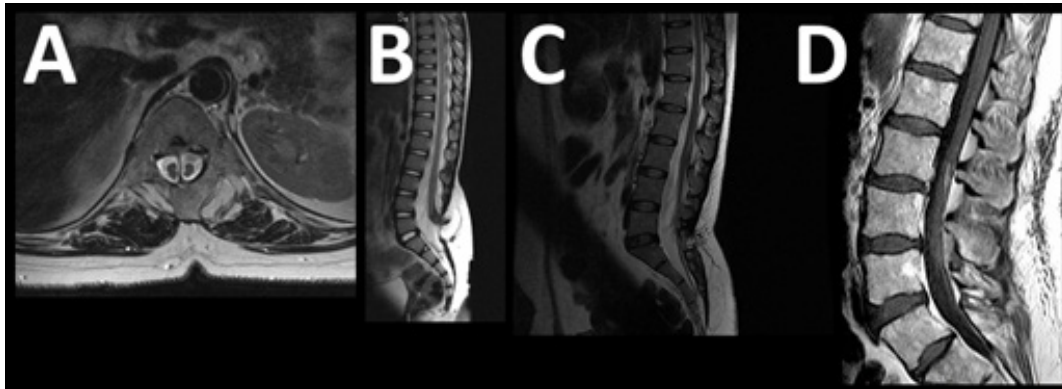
MRI sections shows diastematomyelia in (A), lipomyelomeningocele in (B), tethered cord in (C), tight filum syndrome in (D).
